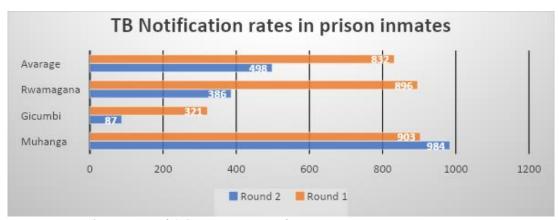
Impact of ACF using x-ray for screening on TB among prisoners
